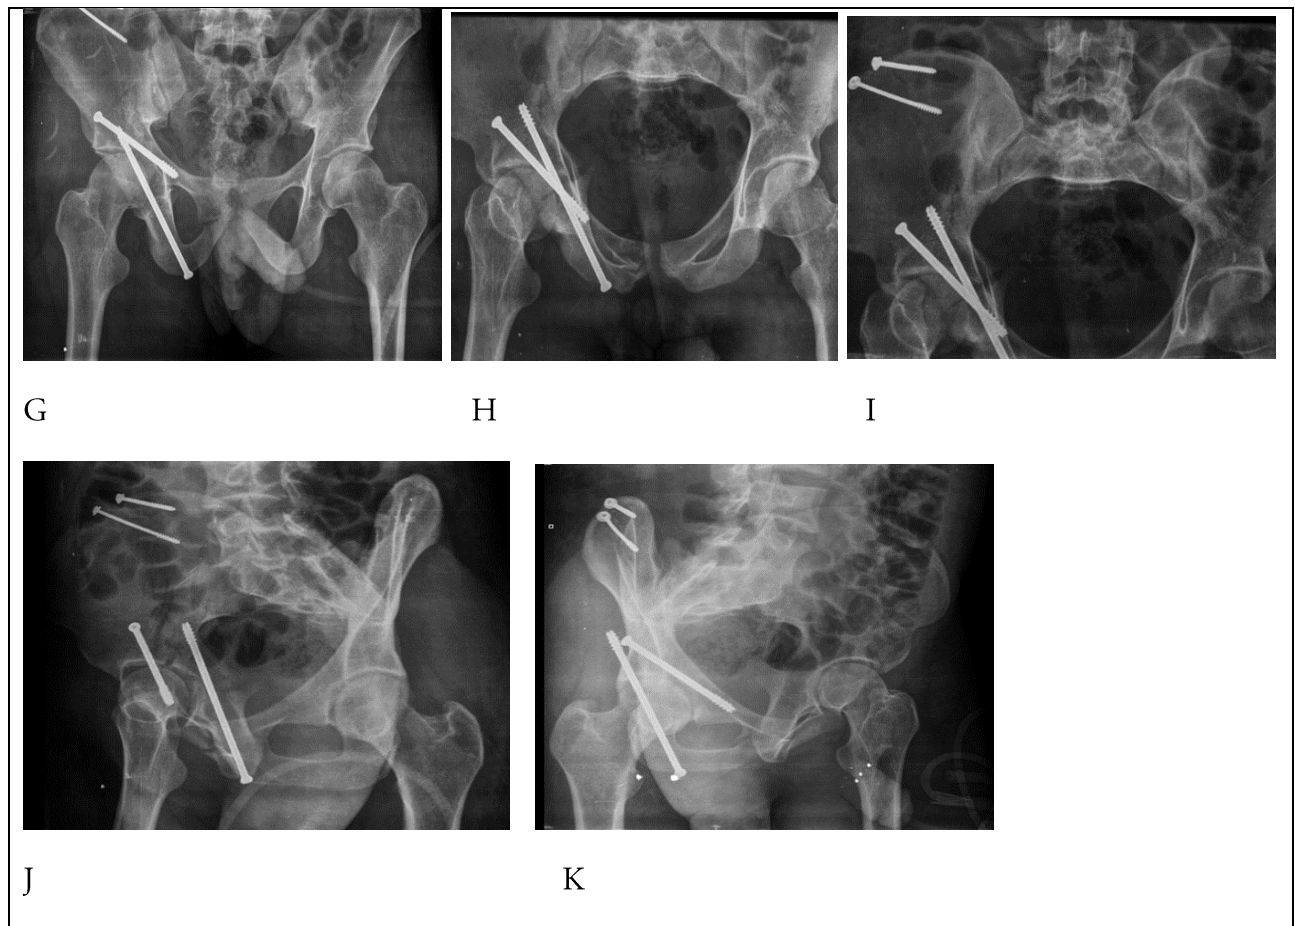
A, B & C (pre op CT axial, sagittal & 3D cuts); D (C arm AP view); E (Post op AP view); F, G, H, I, J & K (Post op Pelvic & acetabular views); I, J, K (pre op CT axial, sagittal & 3D cuts).
